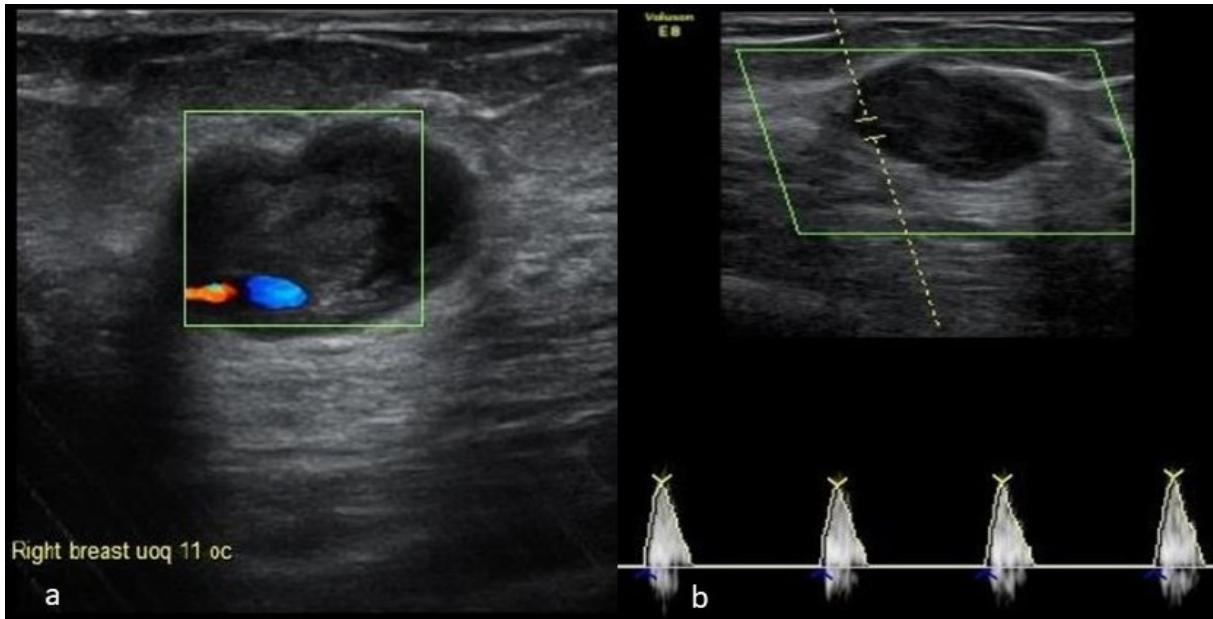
a) A heterogeneous hypoechoic mass with a turbulent flow. b) Spectral color Doppler revealed a to-and-fro waveform in the neck
